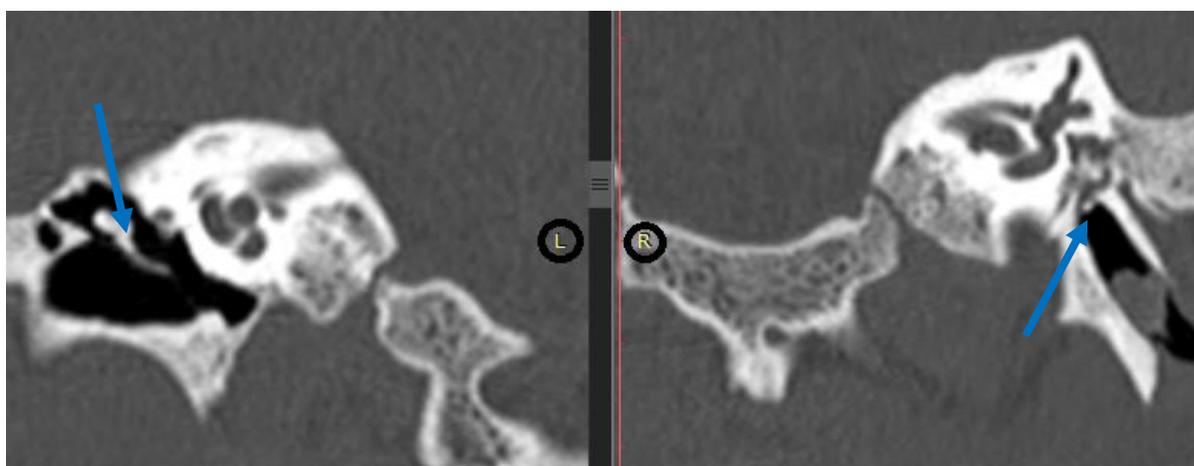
CT axial image showing small left middle ear cavity with few hypoplastic ossicular remnants.(→)
